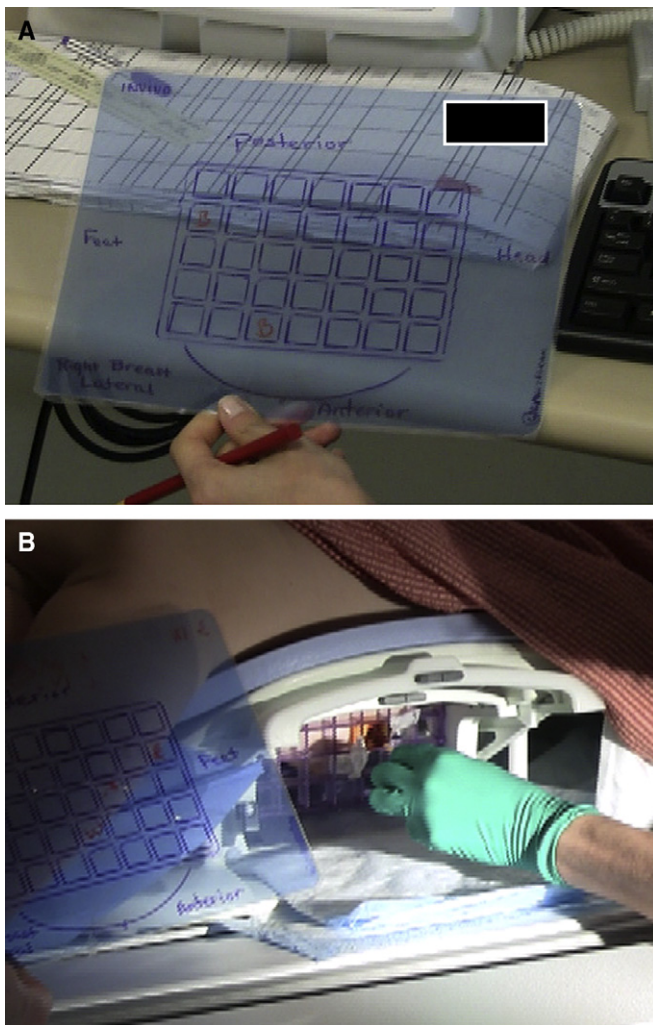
(A) A grease pen is used to document the position of the fiducials (as marked by the letter B) on a laminated depiction of the compression grid. (B) The laminated sheet is then taken back into the MRI suite to guide proper selection of the skin site to be cleaned and anaesthetized.
